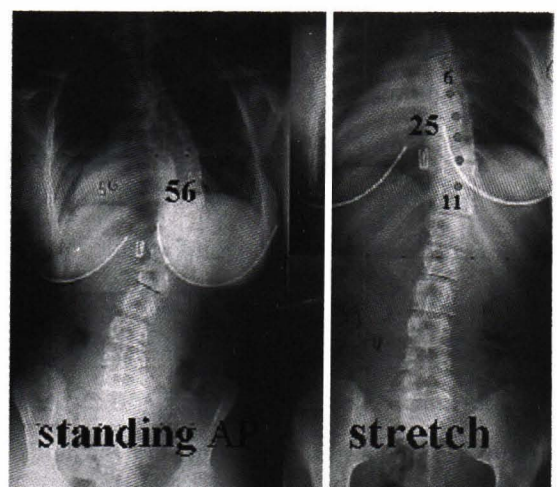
Radiographic demonstration of stretch view compare with AP- standing view.
